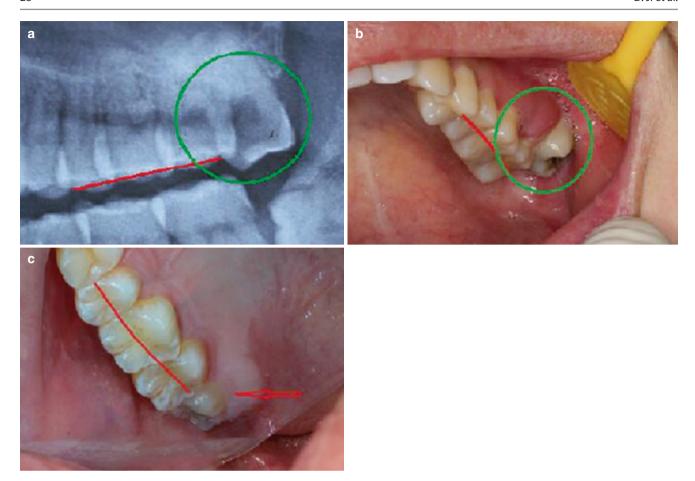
(a) The left maxillary wisdom tooth extrudes and overlaps with the second molar from radiographic examination. (b) The left maxillary wisdom tooth malpositioned and tilted toward the buccal
